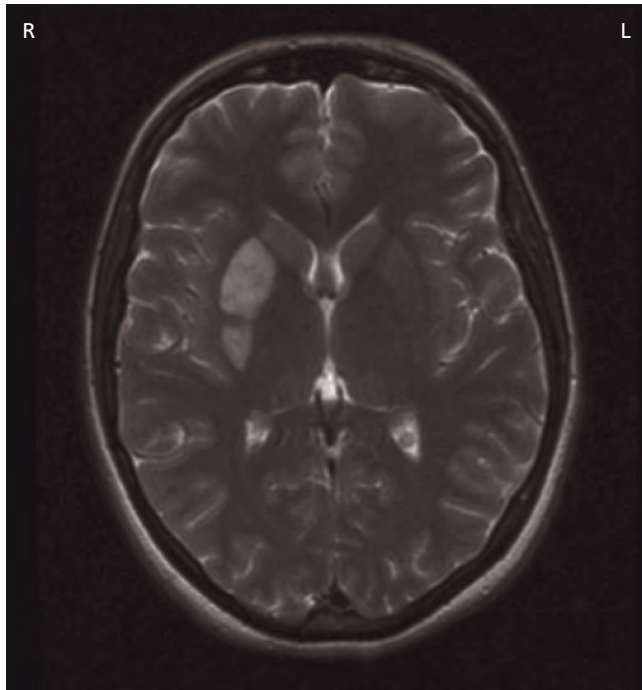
Striato-capsular infarction (MRI T2W).
